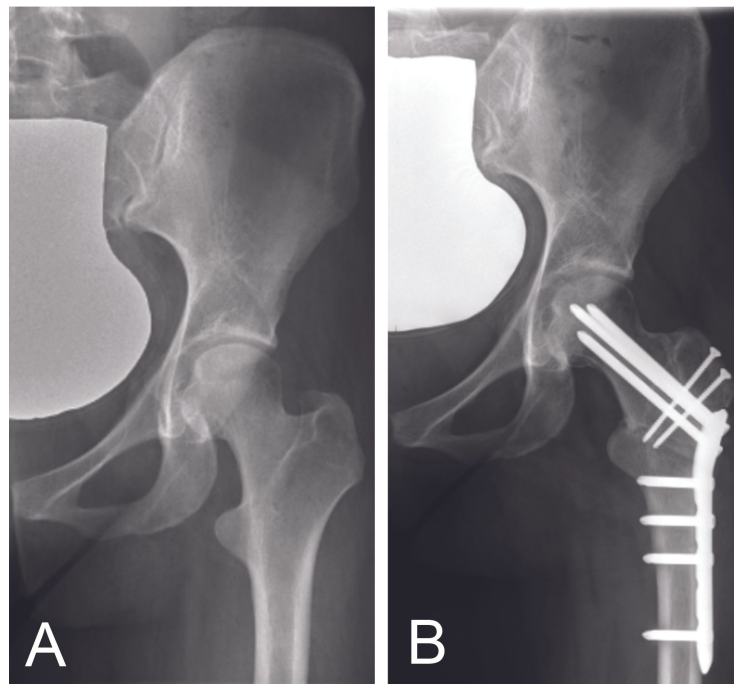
Femoral external derotation osteotomy. Preoperative (A) and postoperative (B) radiographs in a case of femoro-acetabular impingement related to a femoral torsion disorder with exaggerated anteversion, treated by femoral derotation and varus osteotomy.
